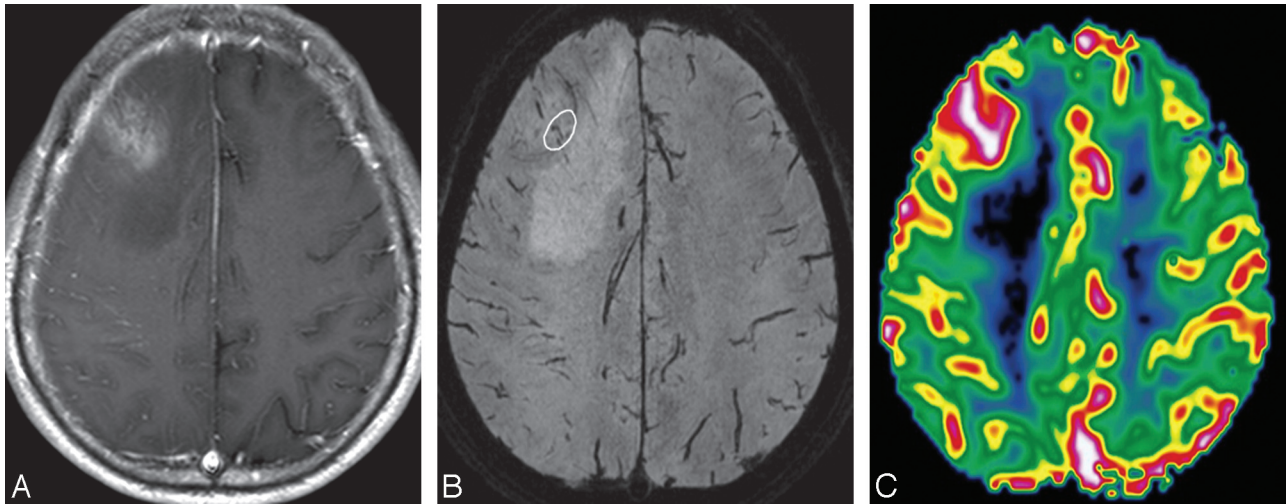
MR images of a 53-year-old man with a right frontal anaplastic astrocytoma. *A*, The contrast-enhanced axial T1-weighted image shows an ill-defined mass with minimal contrast enhancement. *B*, HR-SWI demonstrates a few fine linear and dotlike ITSSs (white circle) in the peripheral area. *C*, Corresponding rCBV map shows a high rCBVmax value of 2.53 in the tumor segment, including maximum degree of ITSS.
